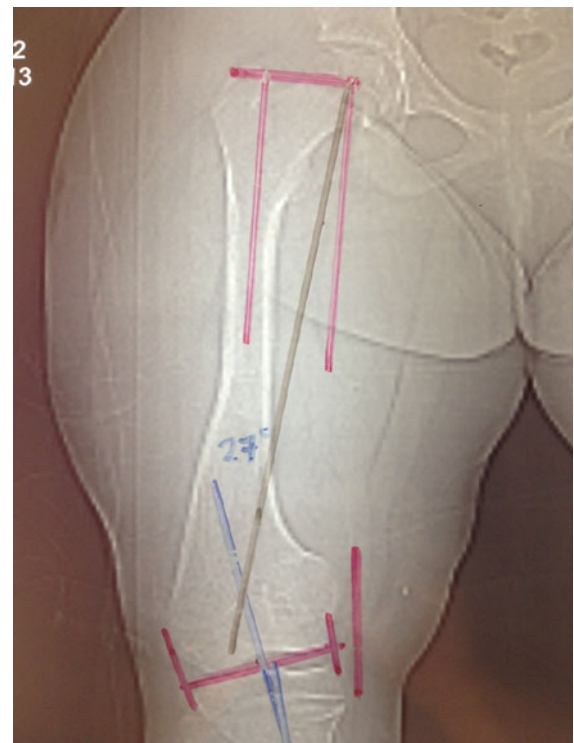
Mechanical axis preoperative planning, right femur, AP X-ray showing 27° varus deformity
